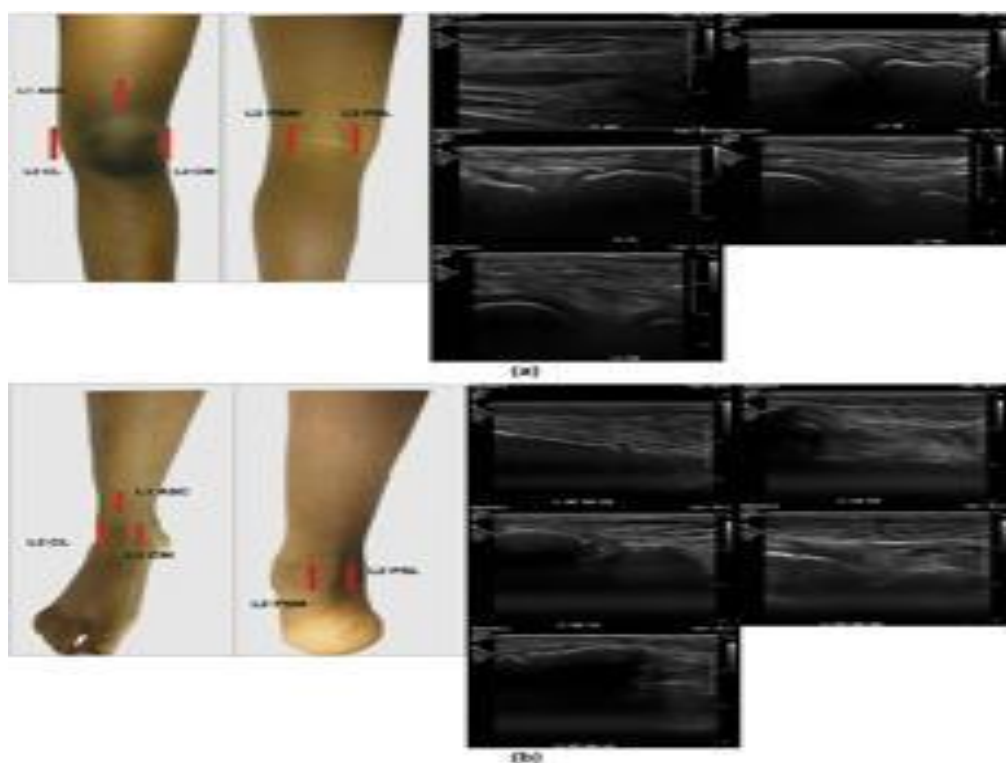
Representative clinical and ultrasound images showing probe placement and sonographic findings in musculoskeletal tendon evaluation.
